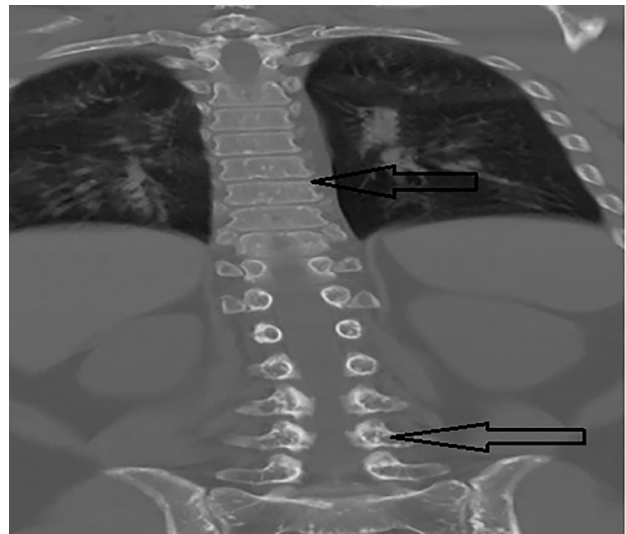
Thoracic and lumbar spine radiograph showing multiple sclerotic foci in the vertebral bodies, indicating axial skeletal involvement
